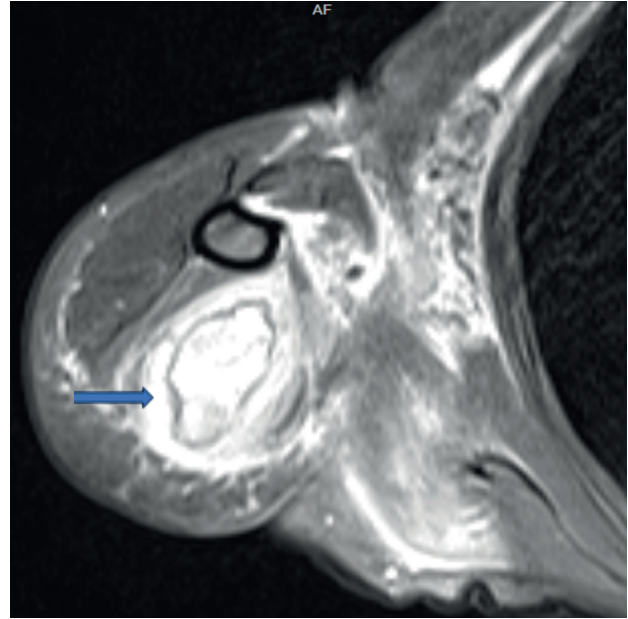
MR image of the hematoma
